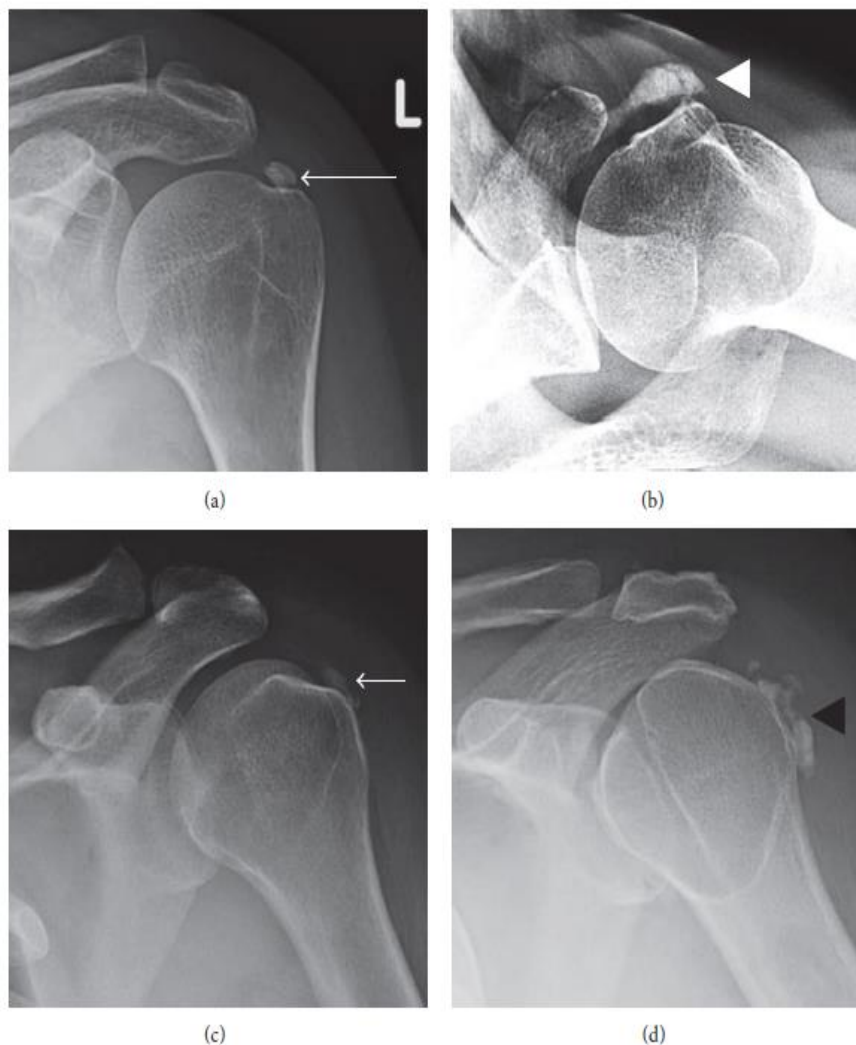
Calcific tendinopathy of the rotator cuff. (a) Calcific tendinopathy of the supraspinatus (long arrow) is best seen on AP shoulder radiograph in external rotation. (b) Calcific tendinopathy of the subscapularis (white arrowhead) is best appreciated on axillary view of the shoulder. (c) and (d) AP views of the shoulder in internal rotation are best for appreciating calcific tendinopathy of the infraspinatus (short arrow) and teres minor (black arrowhead).
